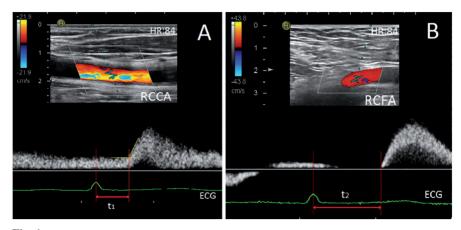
The methodology for measuring pulse wave transit time in the PWV_{cf} determination by echocardiography.
